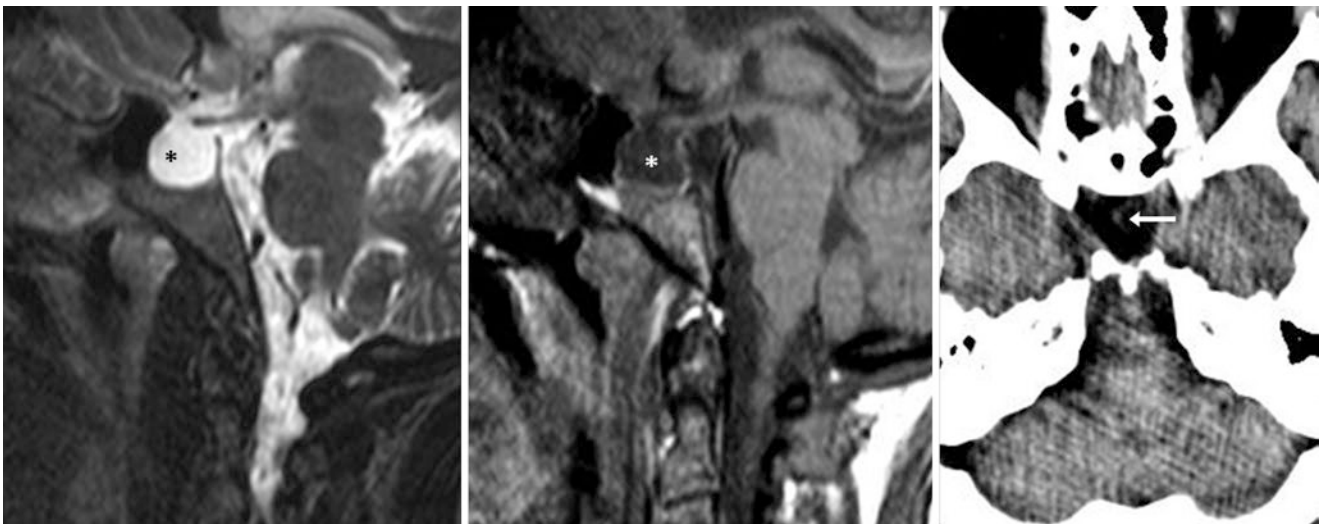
A 47-year-old male patient was seen with neck pain; a complete PES (*) was noted incidentally on a cervical 3 T MRI. The bony contour of the sella is enlarged. The stalk (*arrows*) was not visible on
